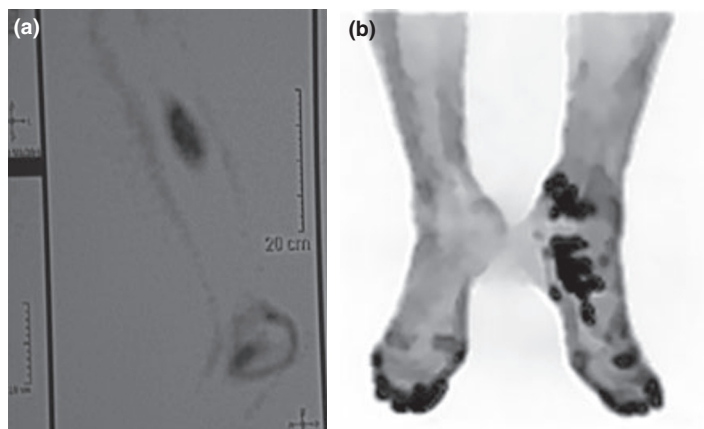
(a) This patient presented with [^{18}F]2-fluoro-2-deoxy-D-glucose ([^{18}F]FDG) uptake in the left limb, and this accumulation was caused by a *Phomopsis* sp. post-traumatic infection. (b) Positron emission tomography with [^{18}F]FDG shows accumulation of the isotope in the left foot, corresponding to a proven Maduraella foot.
